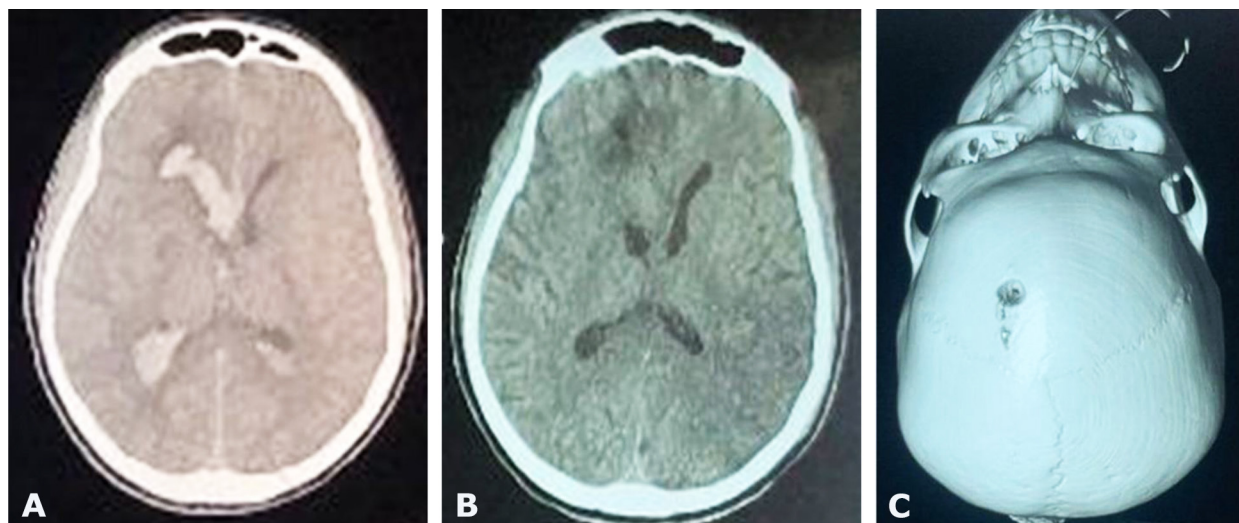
Preoperative CT scan showing IVH (A) and postoperative CT scan showing the complete evacuation of IVH after EVD (B) with the burr hole in 3D (C)
